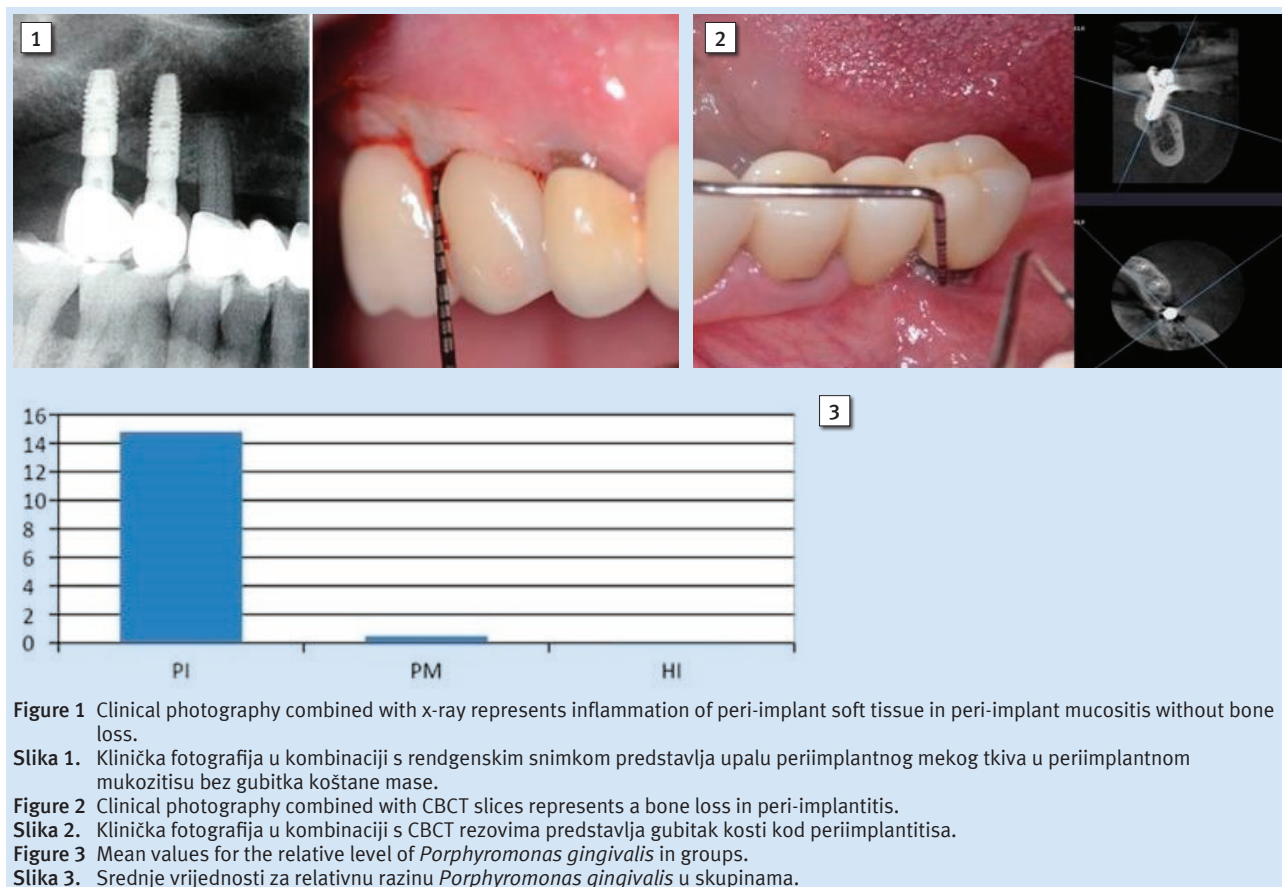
Clinical photography combined with x-ray represents inflammation of peri-implant soft tissue in peri-implant mucositis without bone loss.
